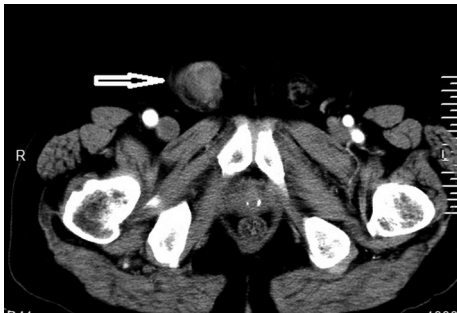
Computed tomography scan showing right cryptorchid testis in the right groin (marked by arrow).
